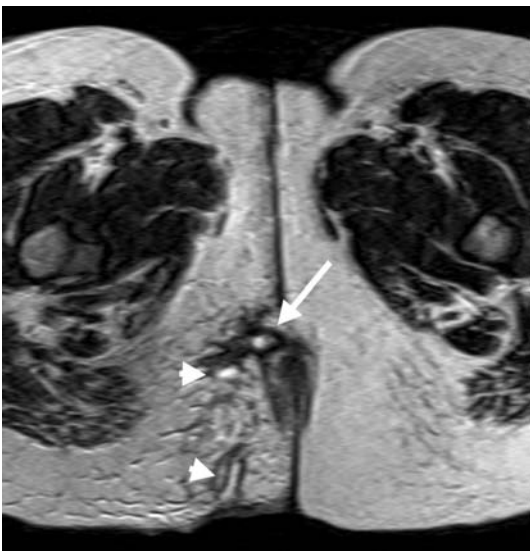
Axial T2-weighted MR image shows a superficial fistula's track (*arrow*) within the ischioanal fossa localized closely to the external sphincter muscle without penetrating it. Secondary tracks are also (*arrowheads*) well visualized.
